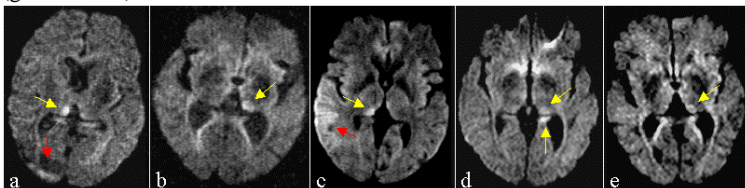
Diffusion-weighted MRI demonstrating involvement of the hippocampus in patients number 3, 4, 8, 13 and 14. High signal abnormality is noted in the right respectively, the left hippocampus (left to right, arrows). Diffusion-weighted MRI hyperintense image artefacts can occasionally be appreciated in the area of the temporal bone.
